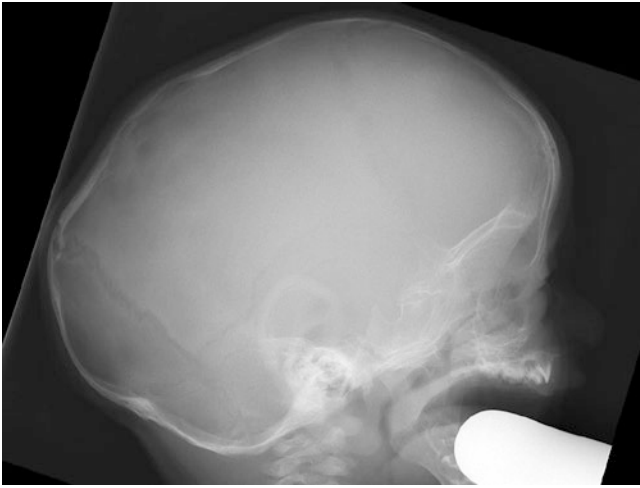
Lateral skull radiograph demonstrating scaphocephaly due to premature closure of the sagittal suture
